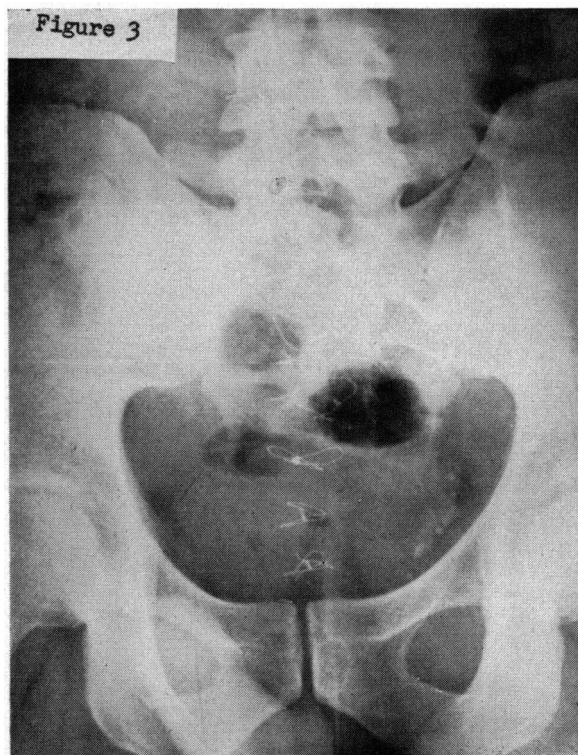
Roentgenogram one year postoperative, showing residual defect of sacrum. Note: No enlargement right second sacral foramen.
